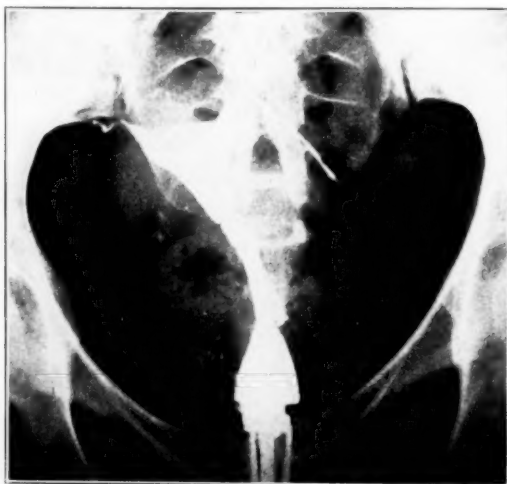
Roentgen lipiodol showing the oil passing the site of attempted closure (no free spill in picture made twenty-four hours later). Note a small portion of right tube visible beyond interstitial portion of tube. The tube had been removed up to the uterus. The angulated tract of oil is taken to be a sprouting of the tubal stump.
